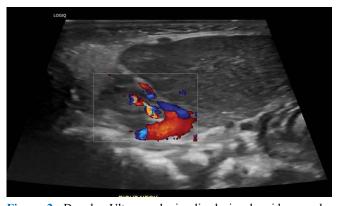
Doppler Ultrasound visualized signal voids vascular structures.
